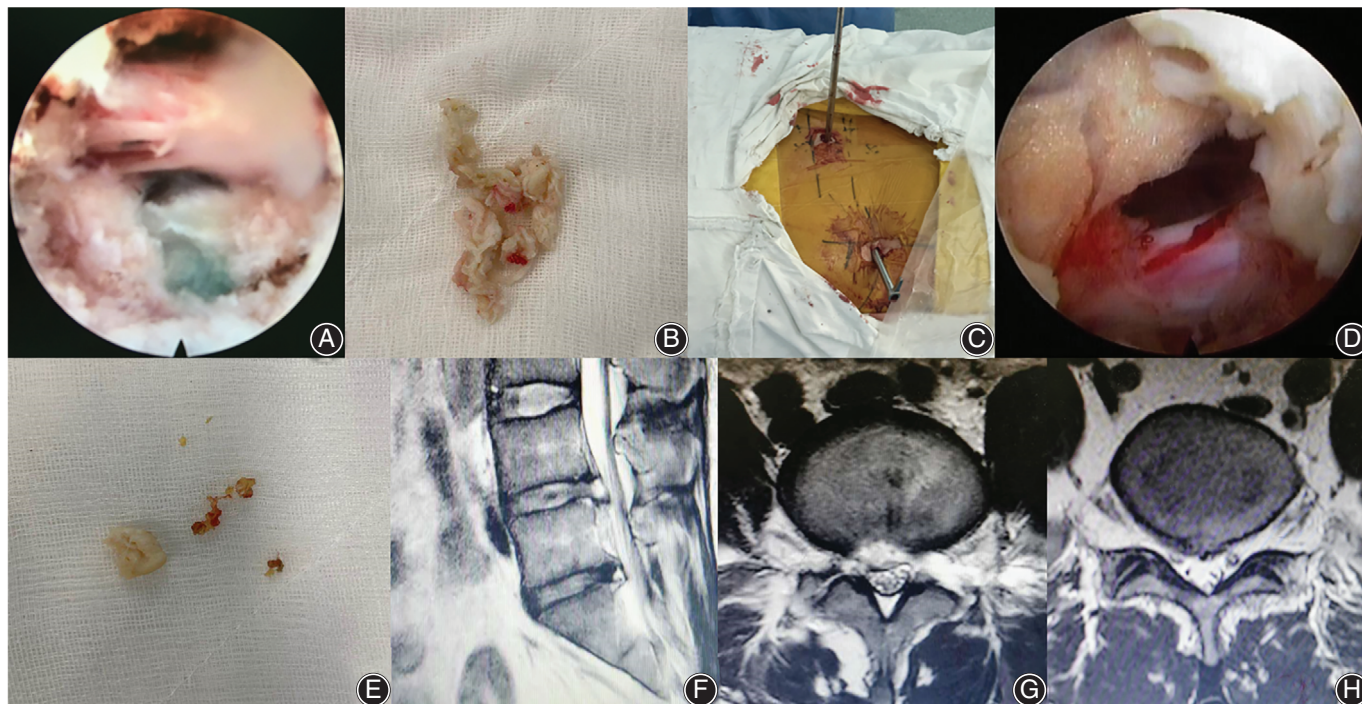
Endoscopic and general view of percutaneous endoscopic transforaminal discectomy (PETD) combined with percutaneous endoscopic interlaminar discectomy (PEID), and postoperative MRI. (A) Endoscopic view of L4/5 after decompression. (B) The removed herniated disc from L4/5. (C) The general view of transforaminal approach combined with interlaminar approach for L4/5 and L5/S1 two-level disc herniation. (D) Endoscopic view of L5/S1 after decompression. (E) The removed herniated disc from L5/S1. (F–H) Postoperative MRI (Day 3) revealed a satisfactory decompression.
